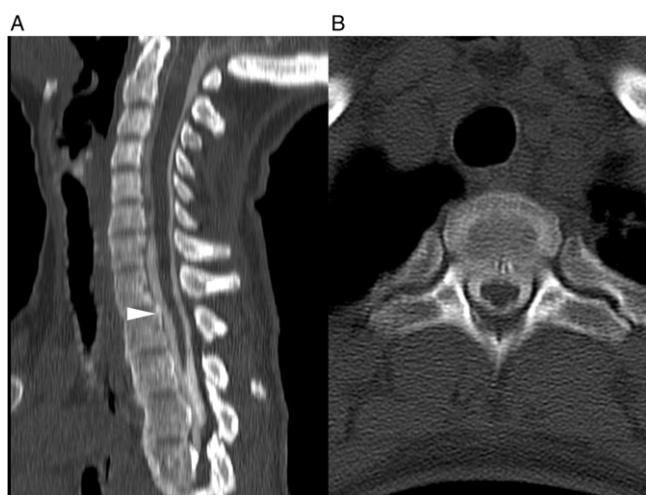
CT myelogram of the cervicothoracic spine. (A, B) Reconstructed sagittal (A) and axial (B) CT myelography images showing extravasation of CSF outside the thecal sac. The arrowhead depicts the precise location of CSF egress and pinpoints the close relationship between the site of fistula and the calcified lesion.
